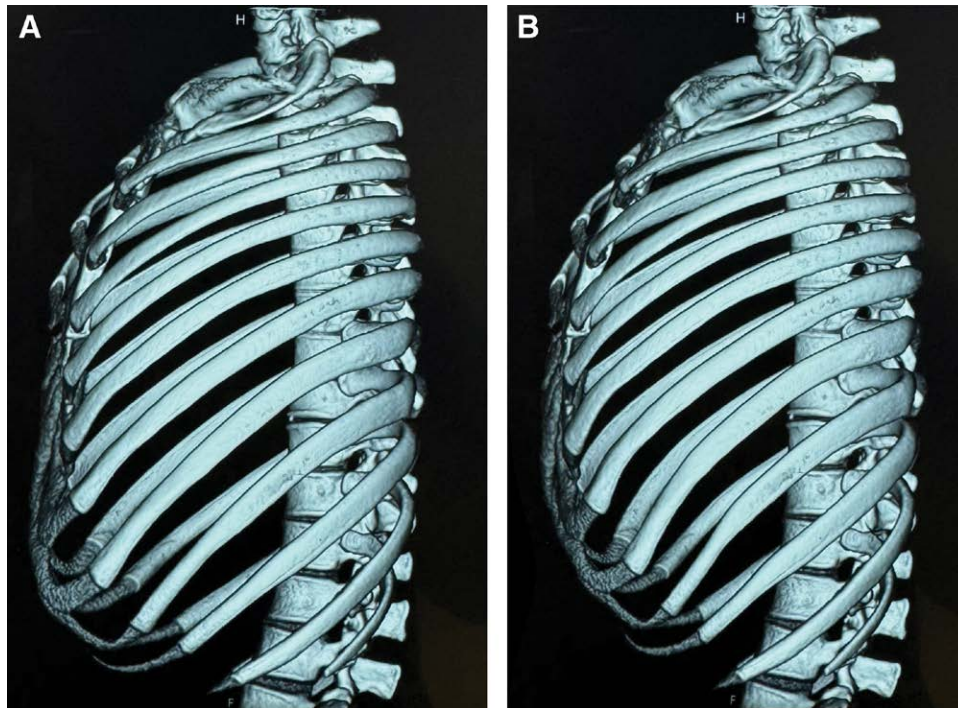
Lateral view of preoperative ribcage CT study of a 30-year-old female patient. A, Preoperative image. B, Six-month postoperative FrontXribs image.
